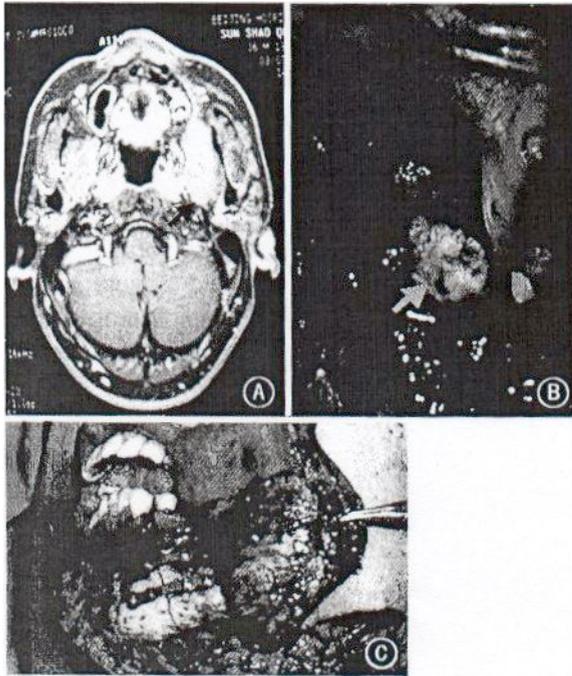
Neurolemmoma of parapharyngeal space. A: MRI shows the mass with clear margin in the parapharyngeal space. B: the tumor was exposed clearly. C: the mandibulotomy was repaired with fixation using previously shaped miniplates.
